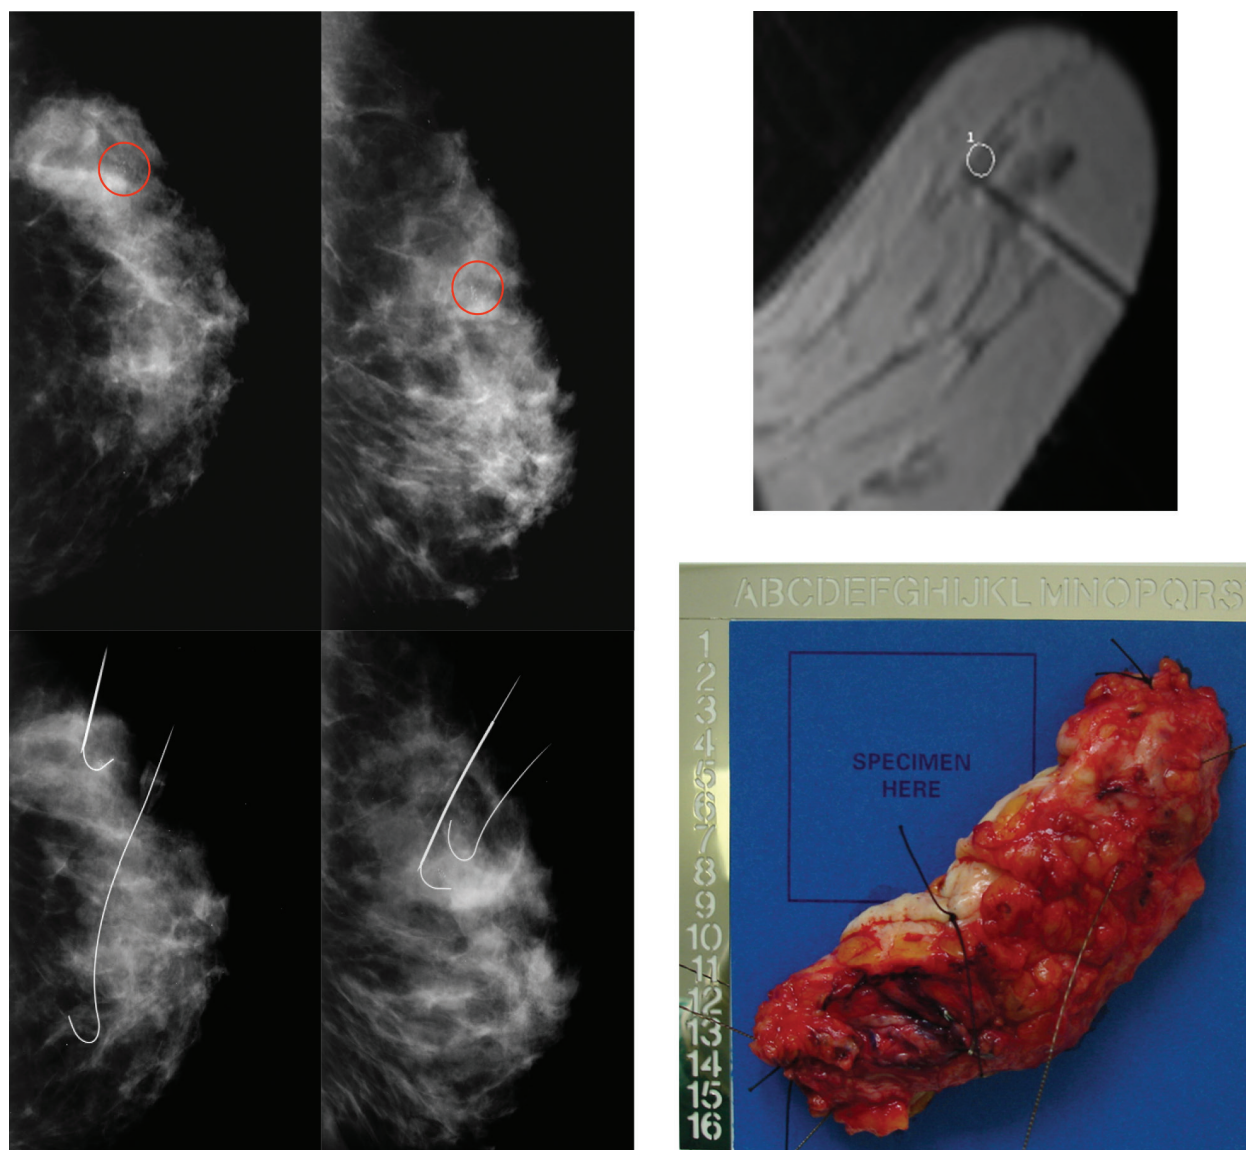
Wire-guided (mammography and MRI) segmental excision.
